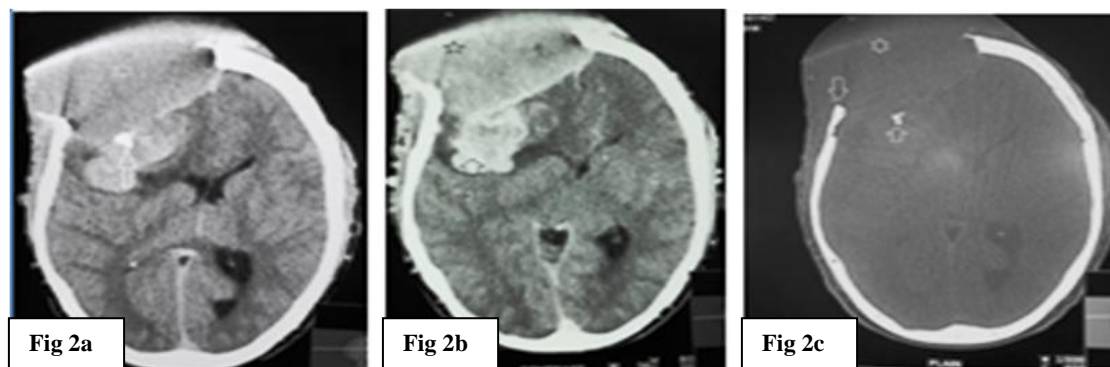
CT Head 2a- Axial section NCCT shows soft tissue swelling on right fronto- parietal region with both extra and intra cranial extensions (white star) along with the patch of destroyed bone (white arrow). 2b - CECT shows mild enhancement of mass (black star) and avid enhancement of its small intracranial extension (vertical black arrow). 2c - Bone window shows extracranial mass (white star) and intracranial destroyed fragment of bone (vertical up arrow) with clear transition zone (vertical down arrow).
